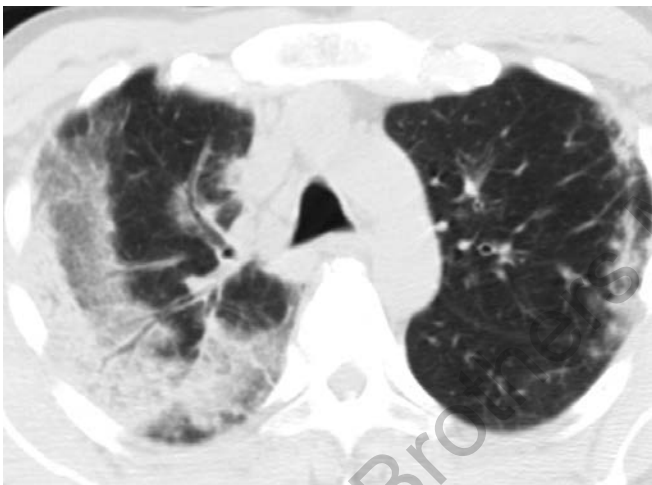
CT chest with peripherally distributed opacities in a patient with chronic eosinophilic pneumonitis
